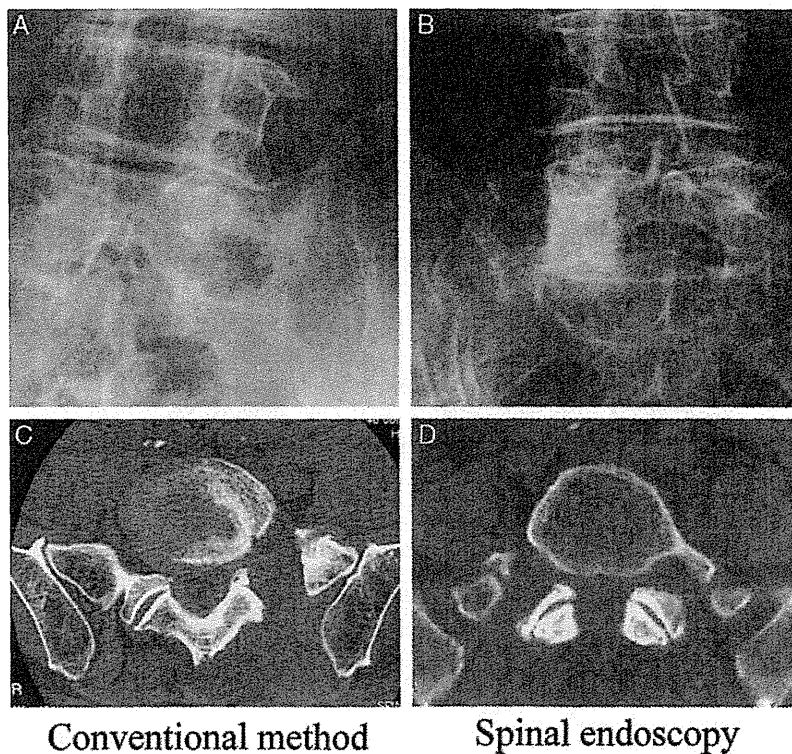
Comparison of the configuration of the L5-S1 facet joint on the plain x-rays and computed tomographic scans obtained after surgery. A and C, The nerve decompression procedure resulted in a total facetectomy after the conventional open method. B and D, Spinal microendoscopy could bypass the prominence of the posterior iliac crest and enlarge the foramen with minimal violation of the L5-S1 facet joint.
